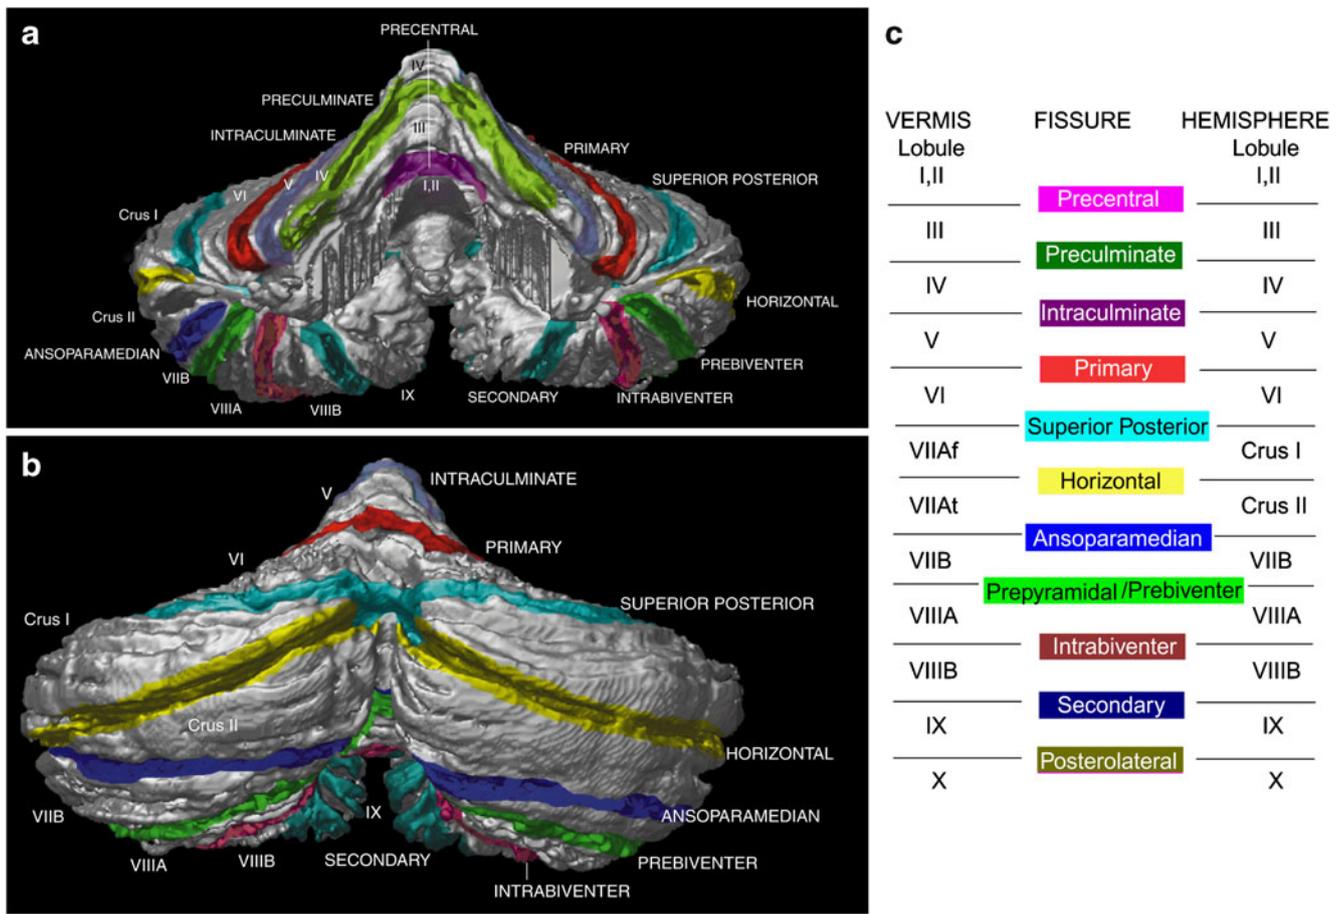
Figures showing three-dimensional reconstructions from MRI of the external surfaces of the cerebellum with the fissures that demarcate the lobules identified in color in (a), anterior view, and (b), posterior view. (c), Table identifying the relationships between lobules
